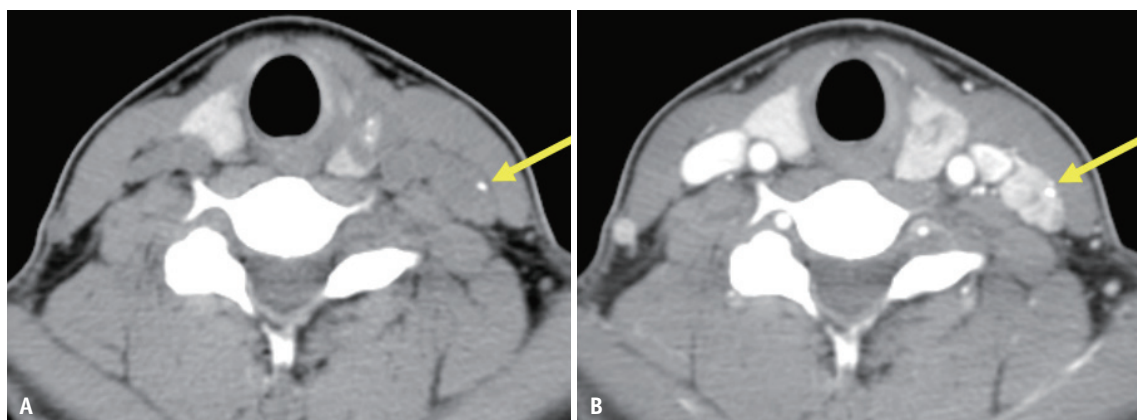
In axial precontrast computed tomography scan (A), the lymph node contains discrete calcification (arrow), and in the post-contrast enhancement image (B), the lymph node shows strong and heterogeneous enhancement without hilar structure (arrow).
